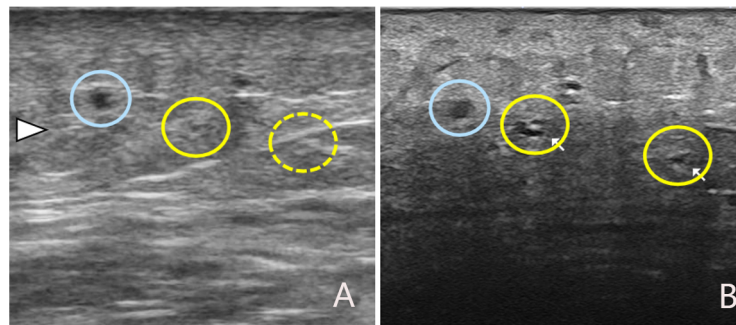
Example of lymphatic ultrasound at the lymphedematous medial calf using different kinds of probes. Blue circles indicate veins and yellow circles indicate lymphatic vessels. White arrowhead indicates a depth of 5 mm. (A) Ultrasonogram with an 18 MHz linear probe (Noblus EUP-L65; Hitachi Medical Corp., Tokyo, Japan). One vein and one lymphatic vessel can be observed. The dashed circle indicates the lymphatic vessel, which we found only after observing it with a 33MHz probe; (B) Ultrasonogram with a 33 MHz linear probe (Aplio i900, Canon Medical Systems Corp., Tokyo, Japan). One vein and three lymphatic vessels are recognized. There are two lymphatic vessels in the central yellow circle. Compared to A, it can be seen that ultrasound is attenuated in areas deeper than 5 mm, making it difficult to observe.
